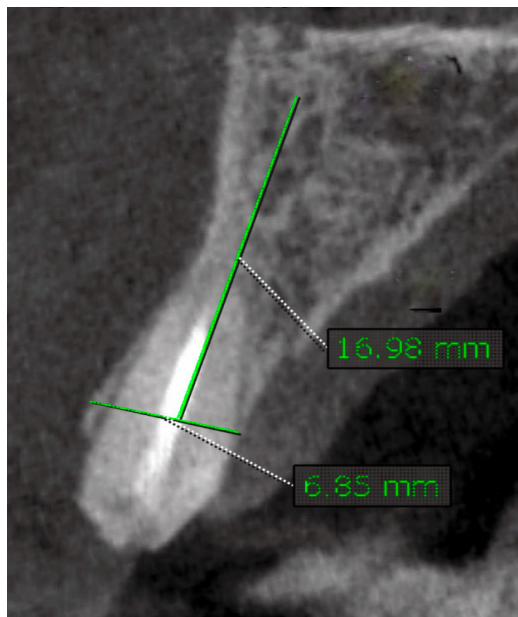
Showing a preoperative cone beam CT with a horizontal bone width of 6.85 mm and a vertical bone height of 16.98 mm
